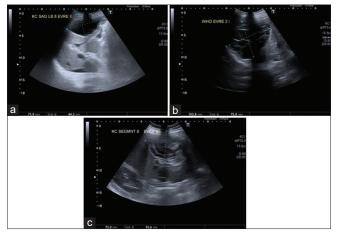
In preoperative B-mode abdominal ultrasonography scanning, there were hydatid cyst lesions located in the liver and the World Health Organization classification was used. Respectively, (a) Type I cyst in the left lobe of the liver, (b) Type II cyst in the right lobe of the liver, and (c) Type III cyst in the right lobe of the liver have been shown. WHO: World Health Organization
